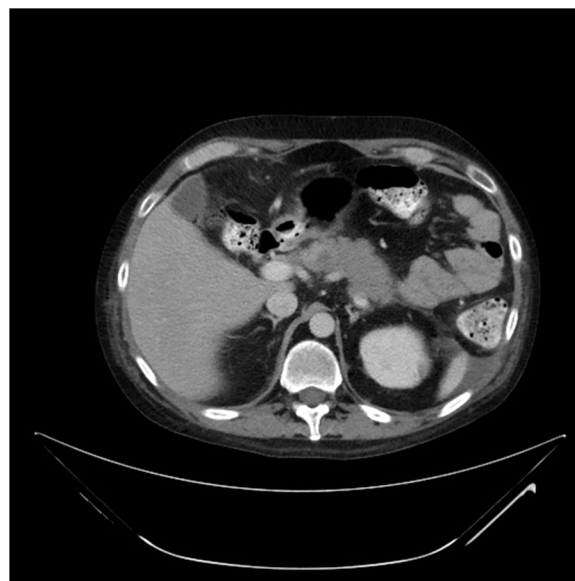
CT abdomen on hospital day 4, with vague 1 cm lesion in pancreatic body.
